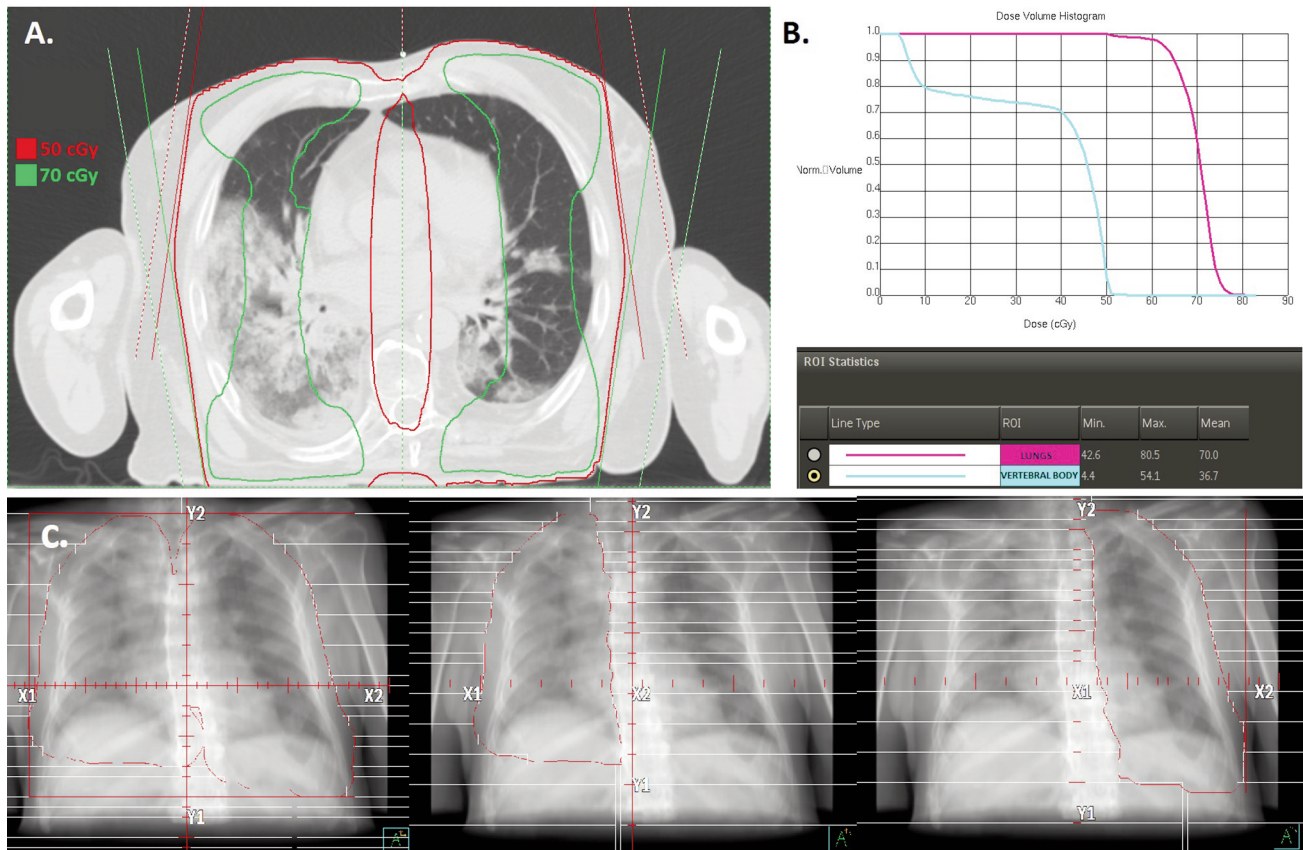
A: Dose distribution and radiation fields of planning computed tomography -scan of patient 2, highlighting the sparing of the vertebral body. B: Dose-volume histogram for the same patient. C: Digitally reconstructed radiographs of the antero-posterior postero-anterior opposing fields, with the principal antero-posterior field conformed with multileaf-collimator to the whole lungs plus 2 cm and two beamlets (field-in-field technique) to treat each single lung minus vertebral bodies.
